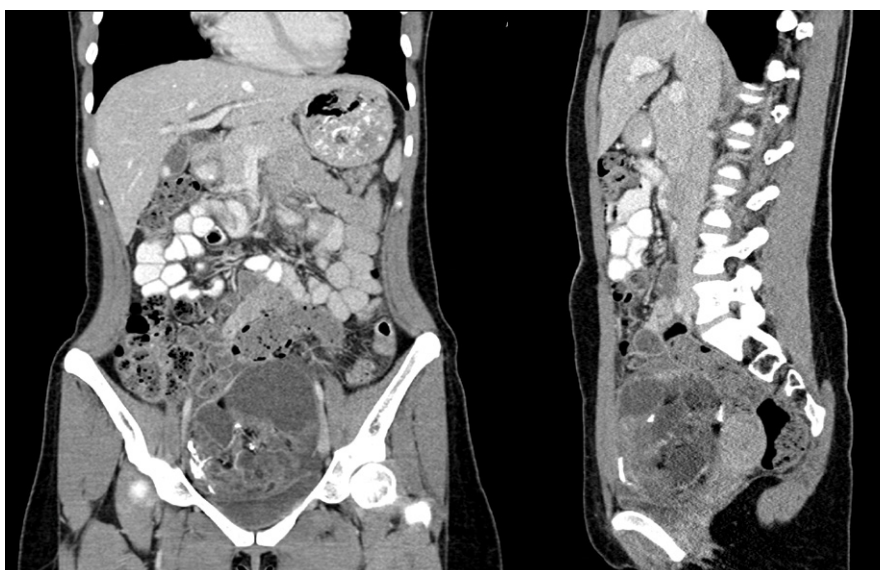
CT abdomen/pelvis (Coronal and Sagittal): A 12x7x11cm multi-loculated solid and cystic pelvic mass, with punctate calcified and fat density foci in keeping with a large ovarian teratoma. No ascites, peritoneal or pulmonary disease, lymphadenopathy or bony lesions. Courtesy of Liverpool Hospital Radiology Department.
